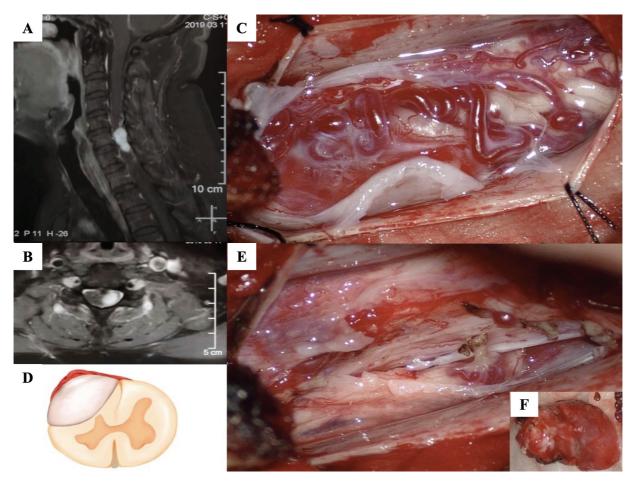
En bloc resection of a thoracic spinal cord hemangioblastoma. Contrast-enhanced T1-weighted sagittal (A) and axial (B) magnetic resonance imaging (MRI) demonstrating a small densely enhancing dorsal spinal cord lesion at the T5–T6 level. (C) Axial MR images for the intramedullary hemangioblastoma. (D) Intraoperative image showing only a small proportion of the tumor localized on the surface of the spinal cord and the large tumor proportion localized in the intramedullary part. (E) Intraoperative image showing complete T5–T6 level tumor resection after circumscribed pial detachment and polar myelotomies. (F) The whole tumor is removed via en bloc resection.
